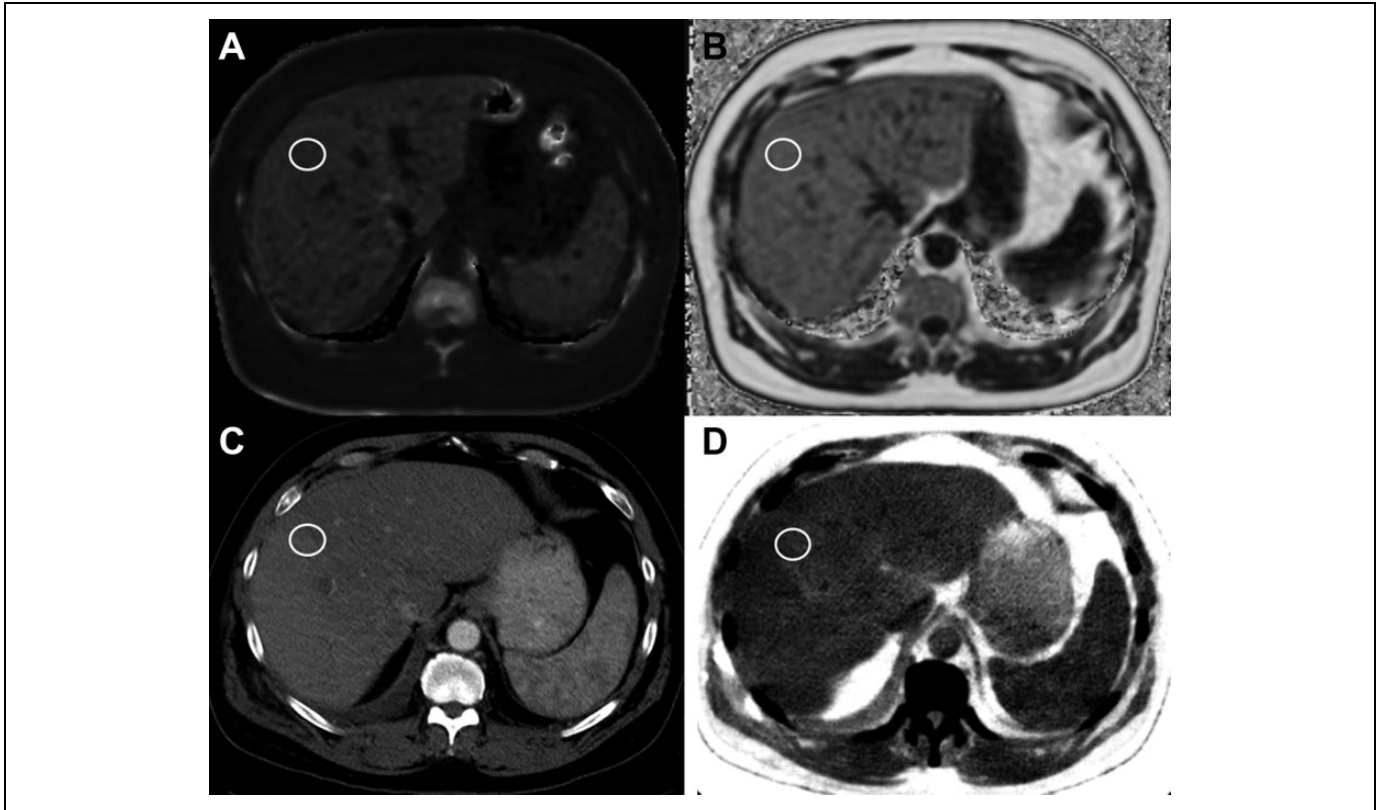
59-years-old male with colon cancer. Steatosis. ROIs traced in the right liver, avoiding major vessels and bile ducts. A) MRI IDEAL IQ sequence, $R2^* \setminus$ IRON map shows that there is no evidence of iron surcharge ($R2^* = 123$). B) MRI IDEAL IQ sequence, PDFF map shows evidence of advanced steatosis: PDFF = 36.2% normal values < 6.6%. C) Monochromatic DECT at 60keV. The placed ROI at the level of the VIII hepatic segment shows an HU of 85. D) FVF map. An ROI placed in the same point as in C gives back a calculated FVF of 20%.
